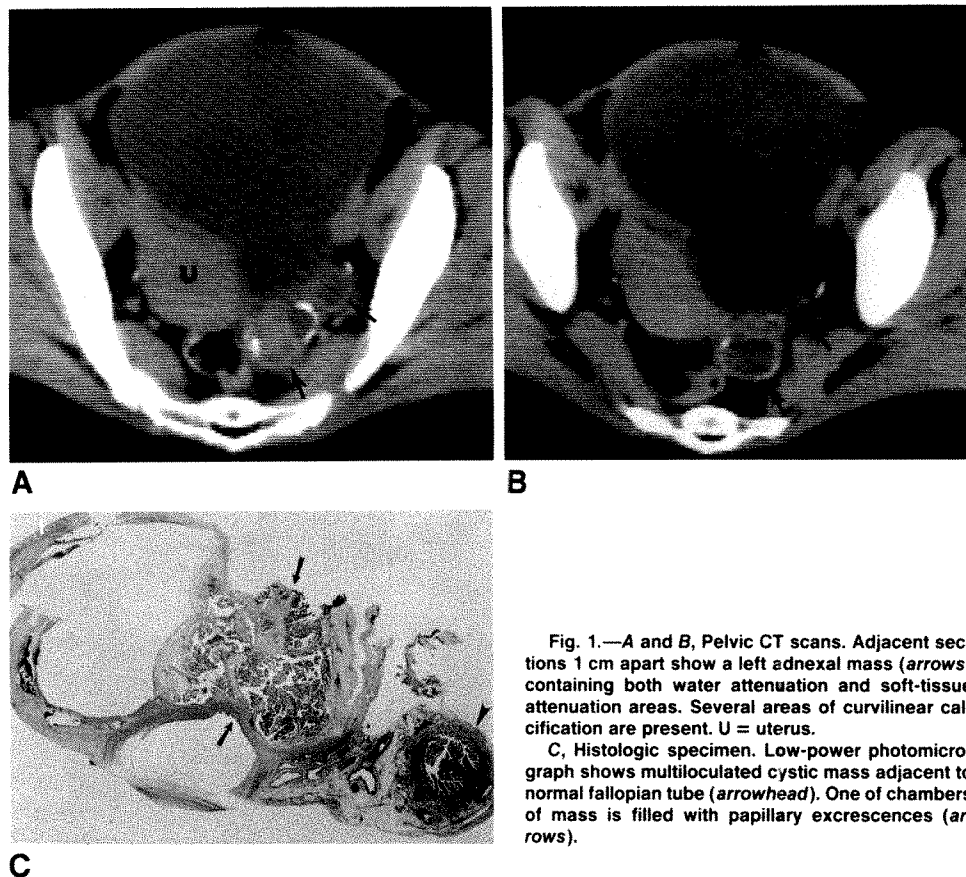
A and B, Pelvic CT scans. Adjacent sections 1 cm apart show a left adnexal mass (arrows) containing both water attenuation and soft-tissue attenuation areas. Several areas of curvilinear calcification are present. U = uterus.
